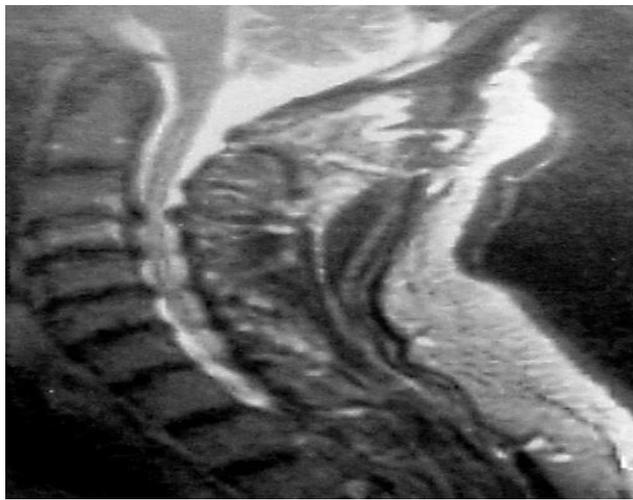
MRI sagittal section of a patient with multilevel cervical myelopathy.
